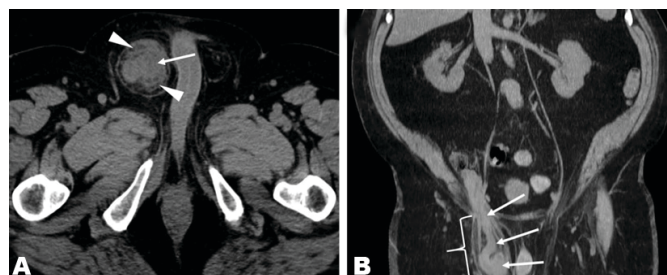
Computed tomography (CT) images obtained without intravenous contrast; (A) transaxial image, (B) coronal image, appendiceal thickening (arrows) and periappendiceal fat-stranding (arrowheads), suspicious for acute appendicitis, the appendix was located within an indirect inguinal hernia sac (bracket), an entity known as an Amyand hernia.
